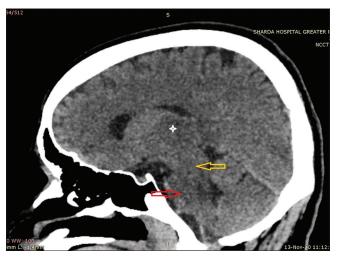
Plain computed tomography sagittal image shows hypodense appearance of Rt. Thalamus (marked with asterisk), midbrain (marked with yellow arrow), and Pons (marked with red arrow)
